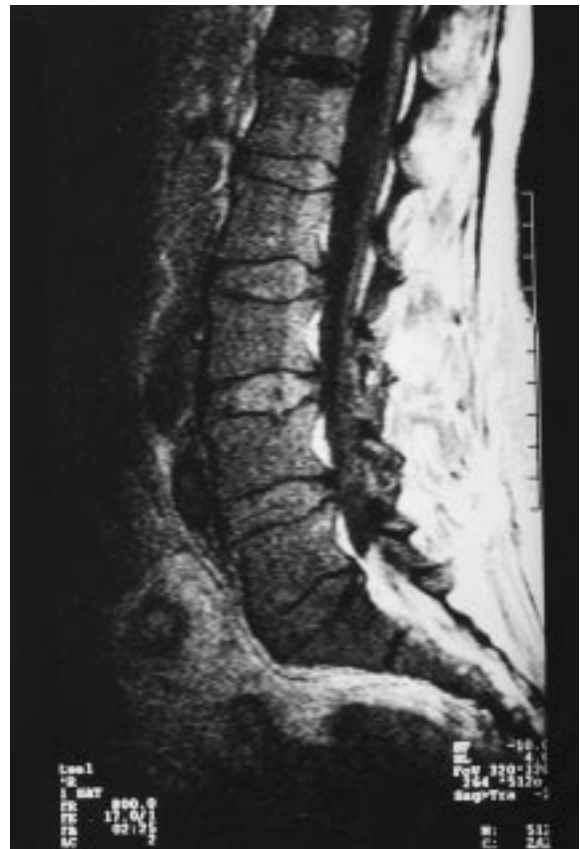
Diffuse signal intensity decrease on T1-weighted images due to diffuse bone marrow infiltration in non-Hodgkin's lymphoma.
